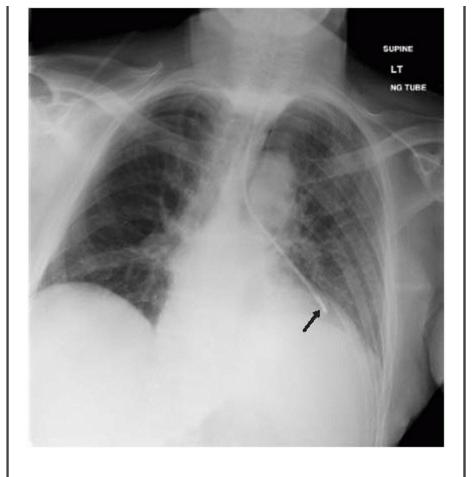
Radiograph showing an NG tube in the left bronchus.
